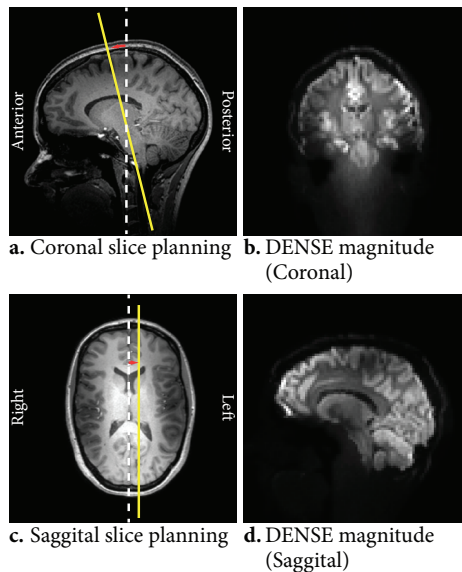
Slice planning of the 2D DENSE scans with respect to the whole-brain 3D T1-weighted TFE planning scan. The yellow lines indicate the planned slices with respect to the interhemispheric fissure, which is indicated by the white dotted line. (a) The coronal slice was planned through the brain stem as indicated in the figure (parallel to the brain stem; subject dependent RL angulation of 12-14 degrees). (c) The sagittal slice was planned perpendicular to the coronal slice, 10mm from the interhemispheric fissure towards the left. (b,d) The DENSE magnitude image as acquired, averaged over all acquisitions.
